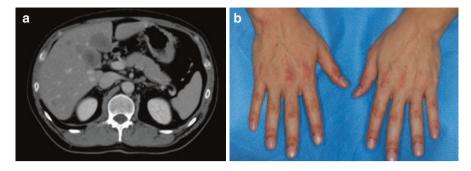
Dermatomyositis and colon cancer. (a) Multiple liver metastases were detected on CT. (b) Skin findings were characterized by erythematous papules that occurred on the dorsal side of both hands (Gottron's sign)
